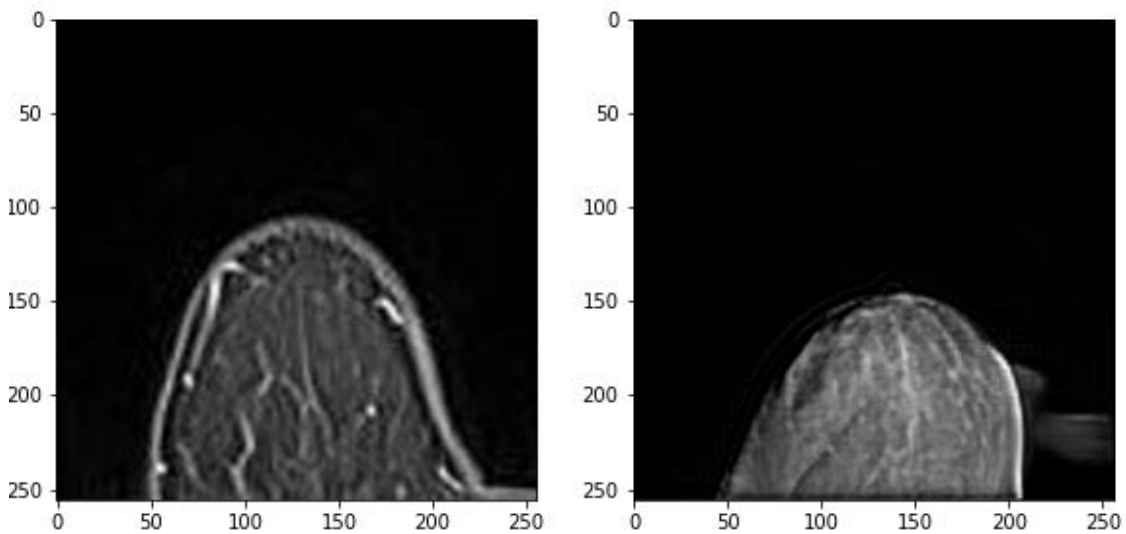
Original breast MRI and sMRI, respectively.
